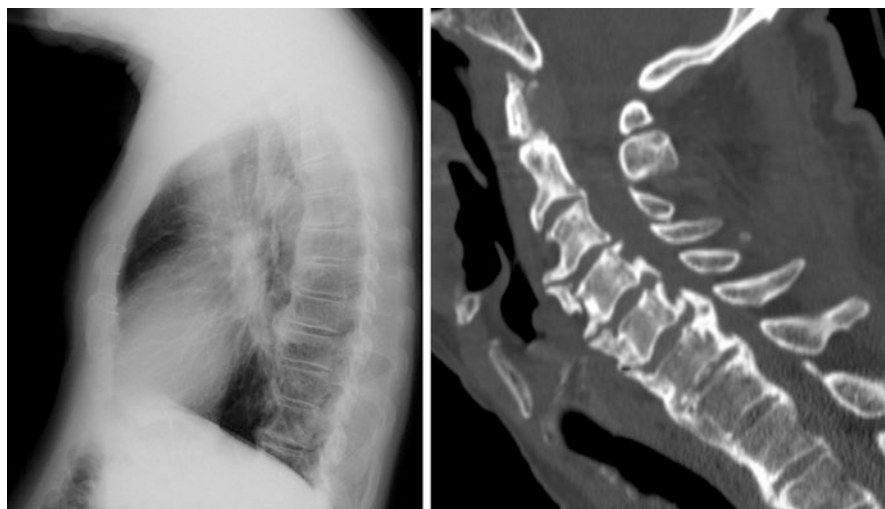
A lateral thoracic spine radiograph (left panel) and a sagittal CT reconstruction of the cervical spine (right panel) of an 83 years old male with diffuse idiopathic skeletal hyperostosis (DISH) demonstrating multiple flowing osteophytes in the anterior aspect of the vertebrae of the thoracic and cervical spine with relative preservation of the intervertebral disc space in these vertebral segments
